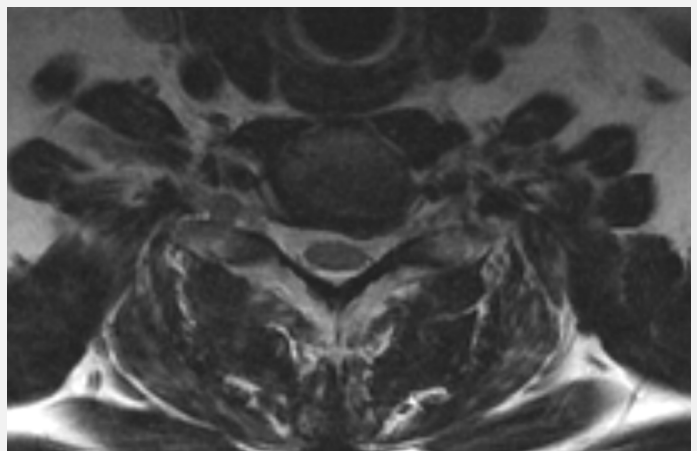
Pre-operative MRI | Axial through C6-7 showing left-sided disc herniation causing some asymptomatic left-sided foraminal stenosis
